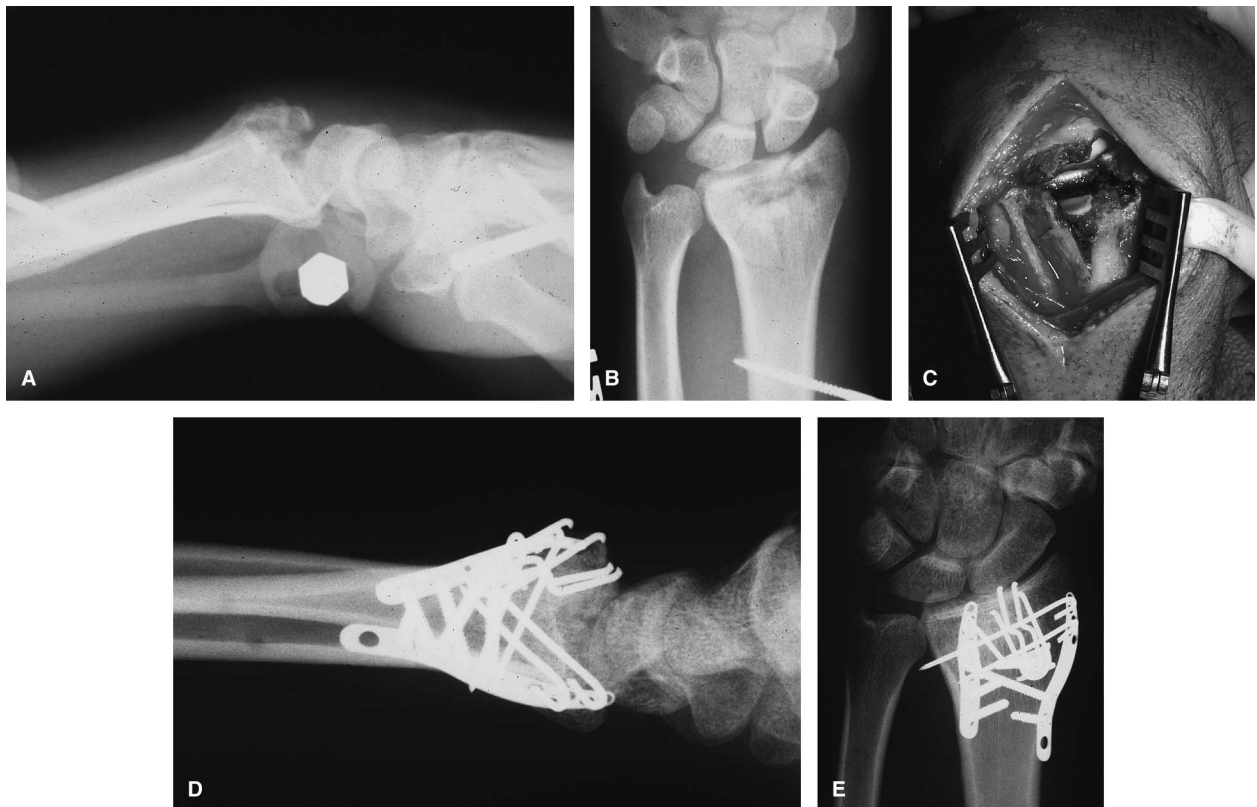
Preoperative and postoperative radiographs demonstrating a displaced intraarticular scaphoid facet fragment. The displaced fragment can be seen on the PA and lateral radiographs that were taken after application of an external fixator. The intraoperative picture demonstrates both the size and displacement of the articular fragment. The fragment was elevated and supported with cancellous bone graft. Further support was provided by placing the distal end of the inner clip firmly against the subchondral surface of the (now) elevated fragment. The lateral postoperative radiograph shows how far distal the distal end of the inner clip was placed.
